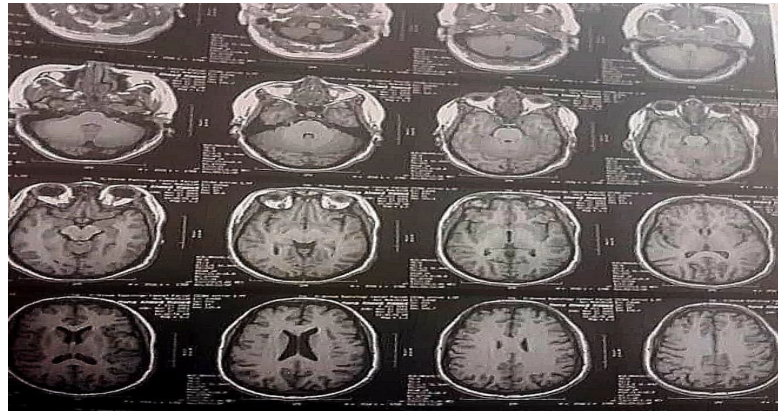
Brain MRI Showing Partial Empty Sella Features, with Enhanced Fluid Signal Projection of the Left Optic Nerve Sheath
